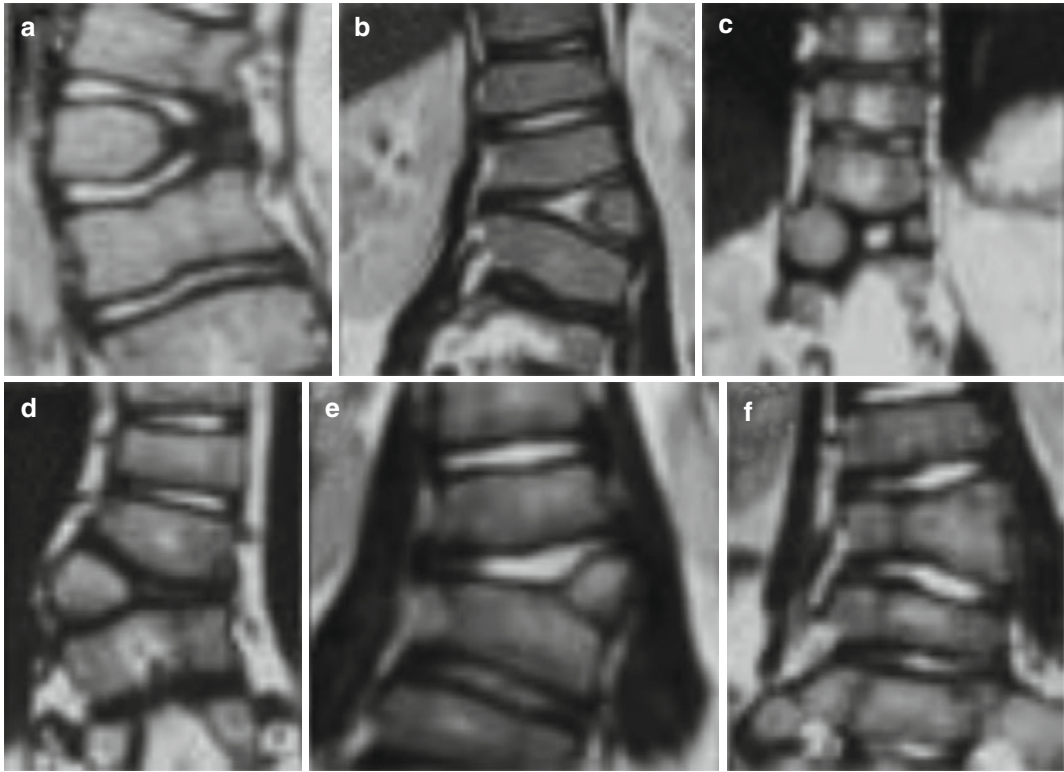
(a–f) Magnetic resonance imaging (MRI) of different types of hemivertebras and the discs around malformed segments
